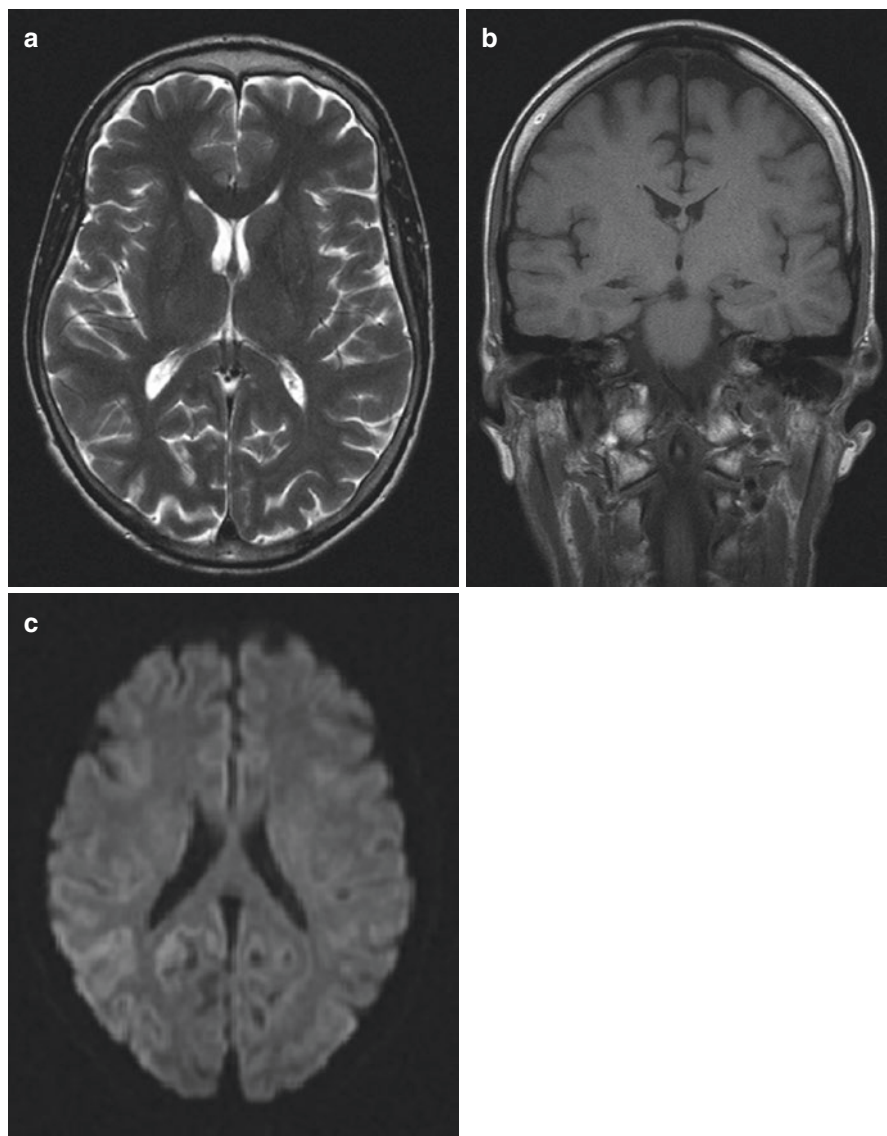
(a, b) T2 weighted axial and T1 weighted coronal MRI which are within normal limits; (c) notice a subtle restriction in diffusion in the right hemisphere cortex posteriorly on diffusion weighted imaging
